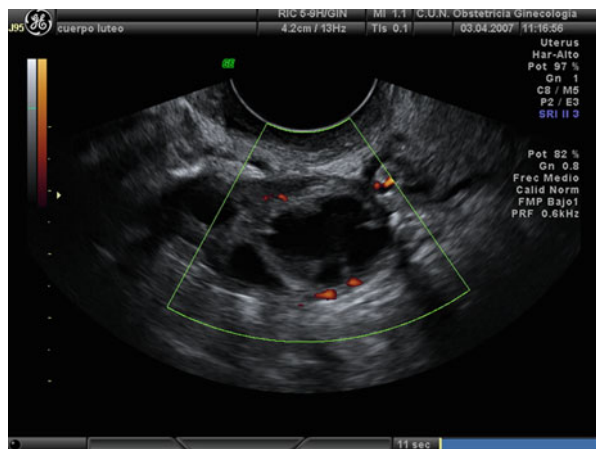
Transvaginal ultrasound picture of a corpus luteum
